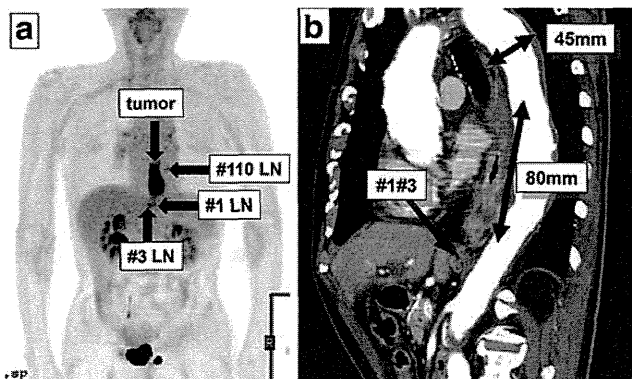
a Positron emission tomography and b computed tomography showed lower thoracic esophageal cancer with #1 and #3 lymph node metastases
